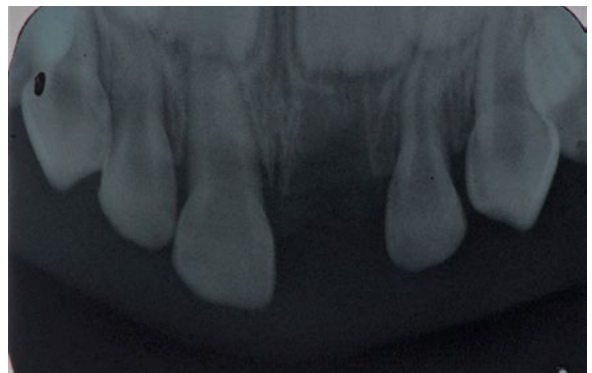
Diagnostic radiography, modified occlusal of the upper arch, showing the absence of the deciduous left upper central incisor in the 36-month-old female child 48 hours after the accident.
